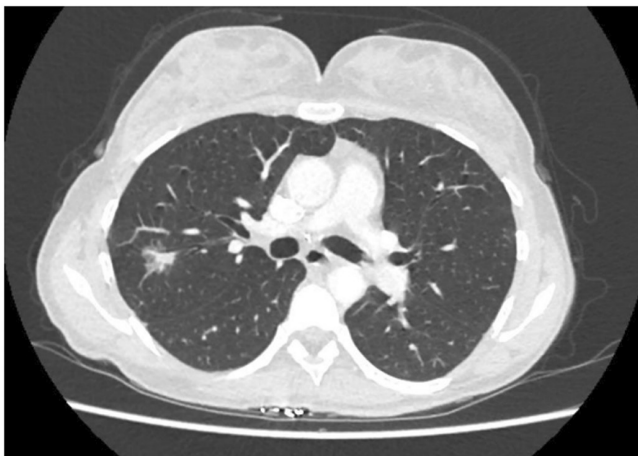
CT image demonstrating right upper lobe posterior segmental ground glass nodules.
